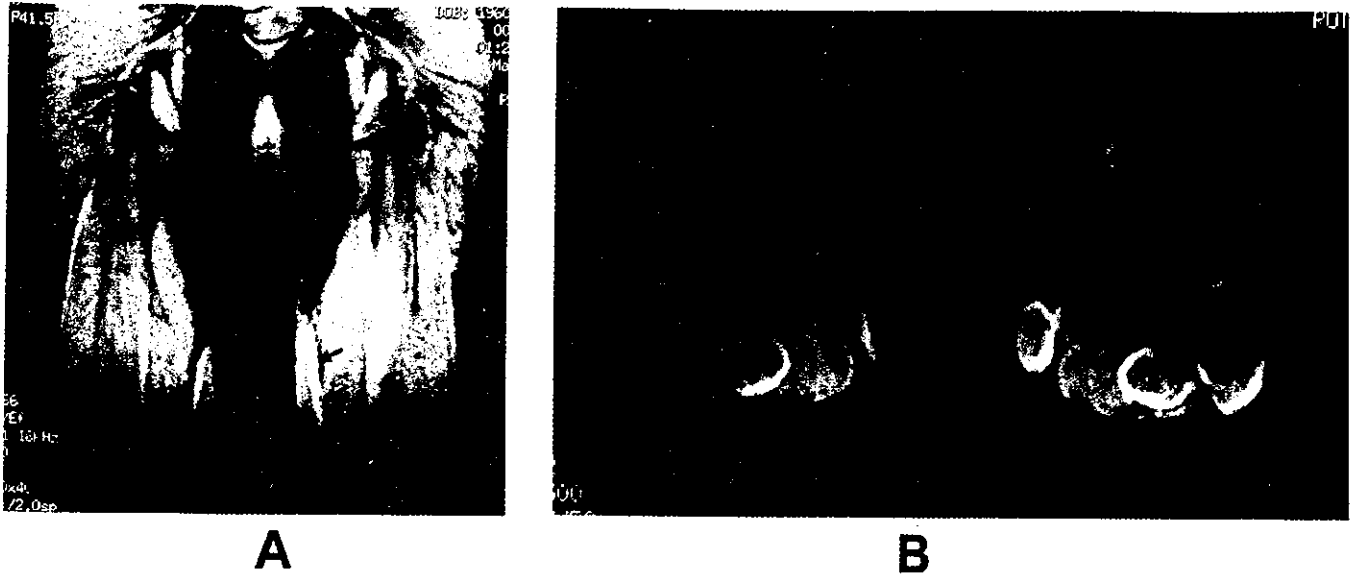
Magnetic resonance imaging of the thigh. Sagittal (A) and coronal (B) views of the middle thighs of a patient with the T61I mutation using STIR magnetic resonance imaging, demonstrating high-intensity signals in fasciâ (arrow).
